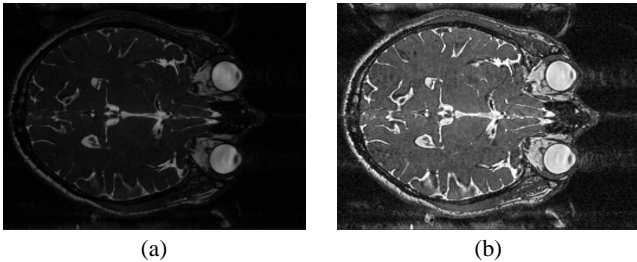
Image slice from MRI CISS dataset. (a) Original 8bit image slice, (b) VHDR enhanced 8bit image slice.
